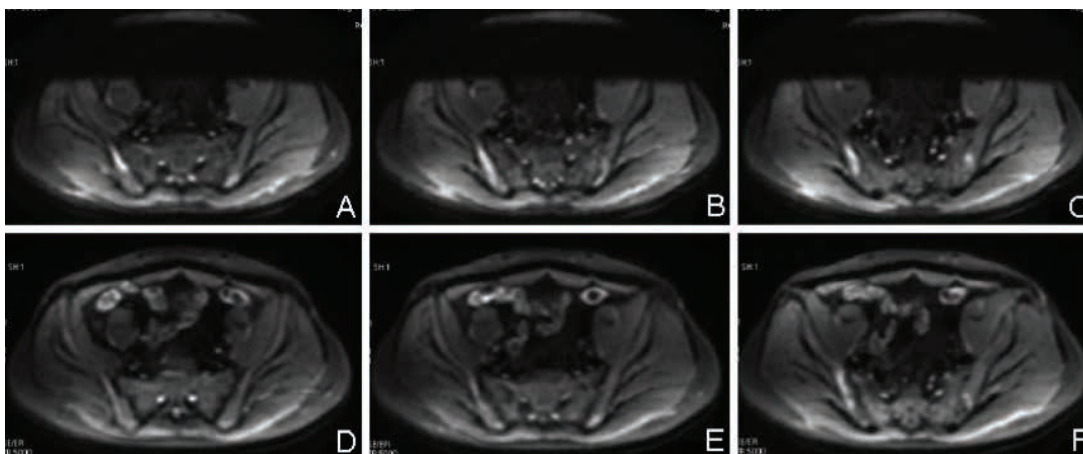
Comparison of DWI image in one patient before and after treatment (A, B, C: before treatment; D, E, F: after treatment). DWI image before treatment showed bilateral post-iliac striped diffusion restricted region; after 4 months' treatment, reexamination showed decreased signal in diffusion restricted region, shrink area and dwindled ADC value, reflecting a good therapy.
